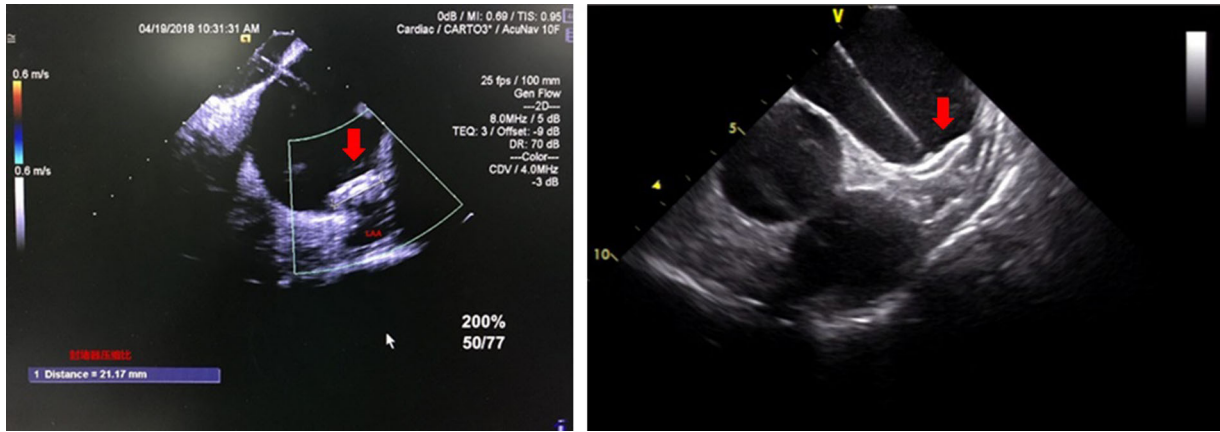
Intracardiac echocardiography (ICE) in the left atrium to guide and assess the device deployment. Left panel, the red arrow indicates the WATCHMAN device; right panel, the red arrow indicates the LAMBRE device [Color figure can be viewed at wileyonlinelibrary.com]
